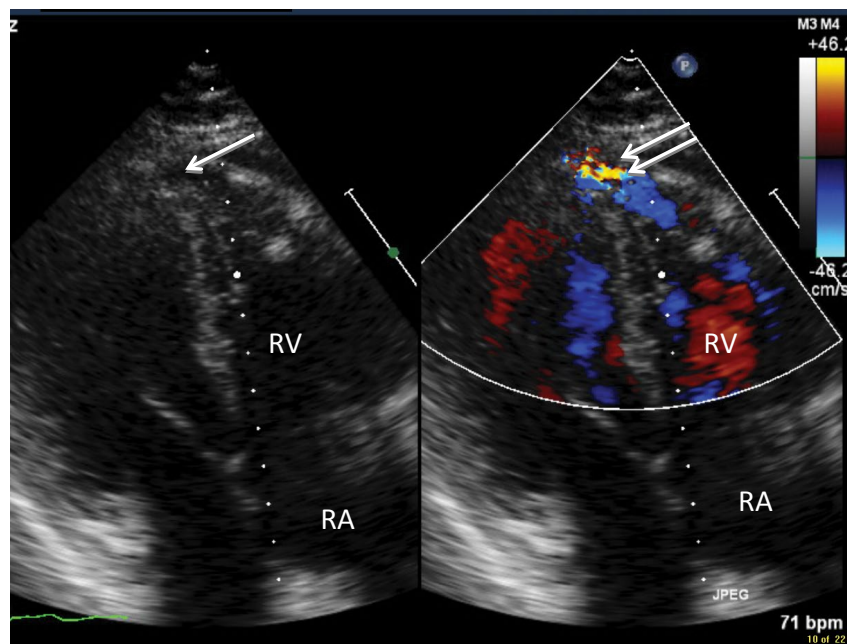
Reverse apical 4-chamber view 2D image (left) and color doppler (right) demonstrating fistula (single arrow) and diastolic flow (double arrow) into the Right Ventricle (RV).
